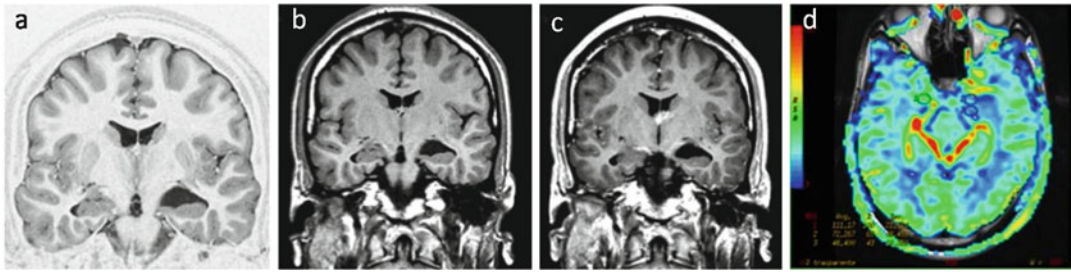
(a) Coronal IR T1 WI, (b) Coronal FLAIR T1WI before and (c) after contrast medium administration reveal an Hypo-isointense DNET that doesn't
